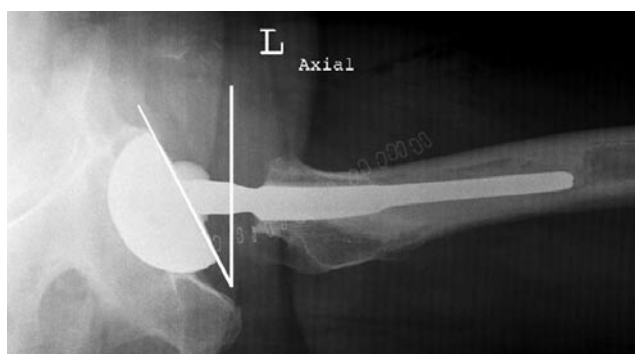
The axiolateral view of the hip, a cross-table lateral radiograph with measurement of the anteversion. Anteversion is measured between a plumb line to the x-ray table and a tangent to the cup.
